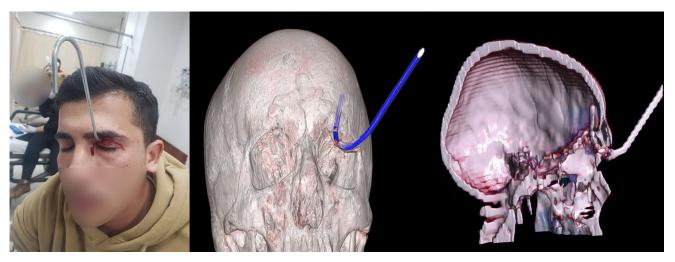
Photograph and a 3-dimensional CT images of the patient who has a perforating injury at the entry location of a metallic bar (S-shaped) that penetrated his left orbit.
